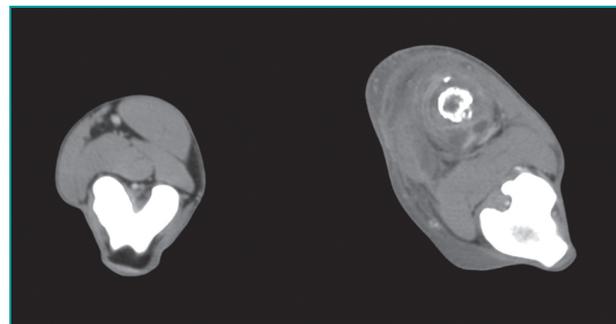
Transverse CT scan, after intravenous administration of a contrast medium, at the level of the right popliteal fossa (standard algorithm, soft tissue window). The swelling of loco-regional muscles is easily recognisable due to the presence of an undefined, calcific density area in its structure; the left limb is relatively normal.
